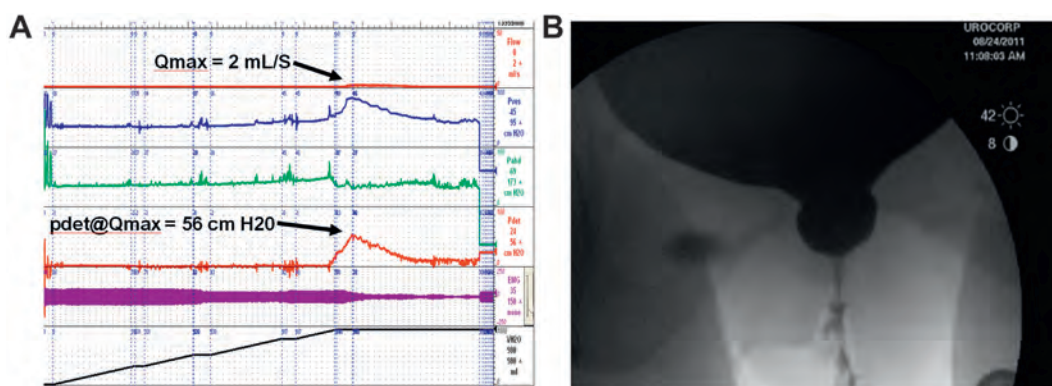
Urethral obstruction 2 years after SPARC™ sling. At surgery sling was embedded in urethral wall but did not erode. A, urodynamic tracing showed severe urethral obstruction, Blaivas-Groutz nomogram type 2. pdet@Qmax, detrusor pressure at maximum flow rate. Pves, vesical pressure. Pabd, abdominal pressure. Pdet, detrusor pressure. EMG, electromyogram. V_{H₂O}, volume of water. B, x-ray at Qmax showed obstruction in distal third of urethra. Patient underwent excision of suburethral portion of sling and subsequently voided normally (Qmax 19 ml per second, voided volume 150 ml, post-void residual 49 ml). However, patient experienced sphincteric incontinence and underwent successful autologous fascial sling 4 months later.
